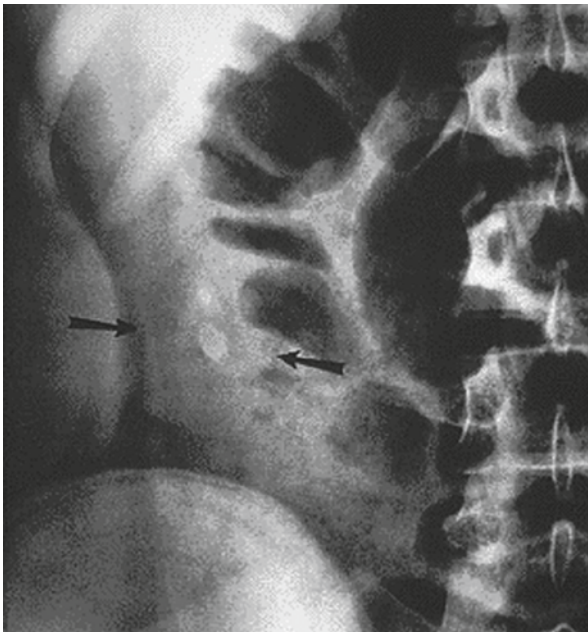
Abdominal X-ray: appendicular fecalith (*arrows*; when visualized in a patient with symptoms and signs of acute appendicitis, it is highly diagnostic)
